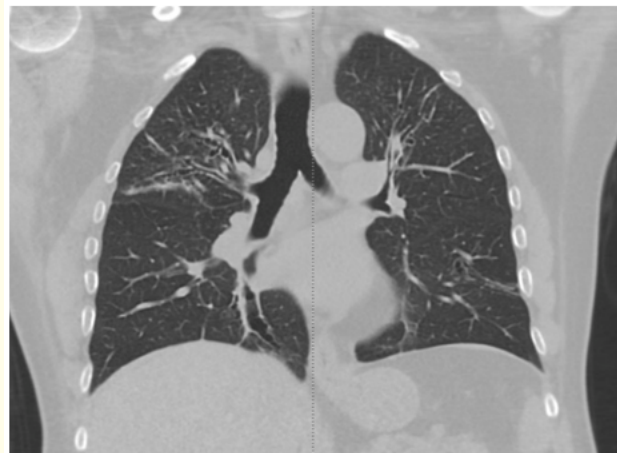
Showing CT scan ray for asthma [7].
